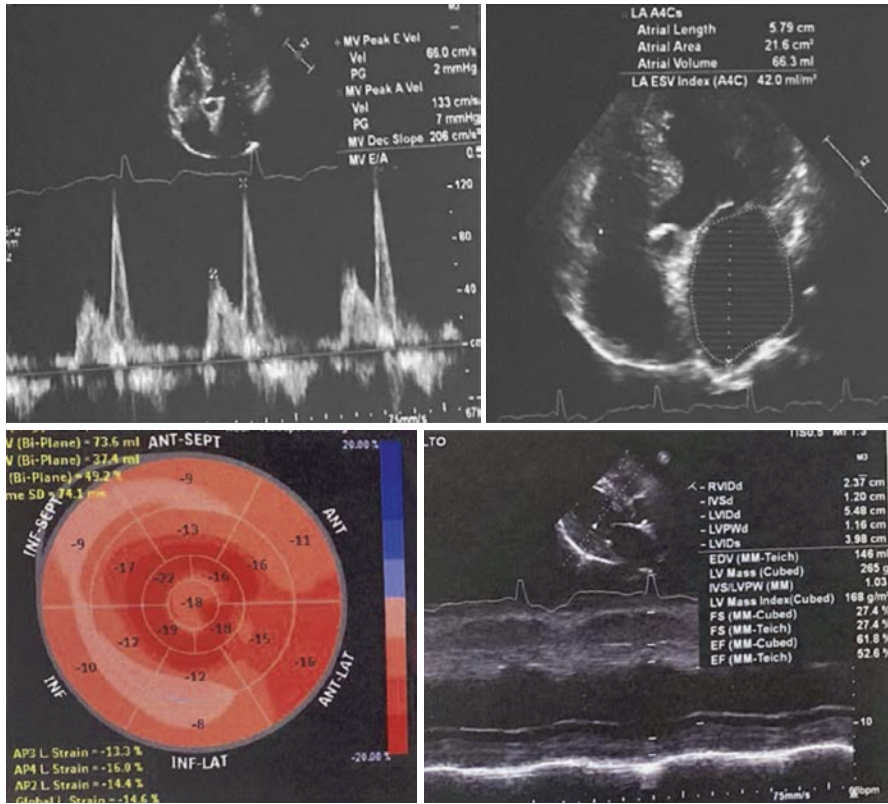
Transthoracic echocardiogram showed systolic function with moderate global deficit, type I left ventricular diastolic dysfunction, mitral valve with moderate reflux, myocardial thickness with concentric increase, and enlarged left heart chambers. The septum and posterior wall were both 12 mm. Longitudinal global strain with more evident dysfunction in basal areas with apical preservation, GSL—14.6%, and two-dimensional ejection fraction of 52%
